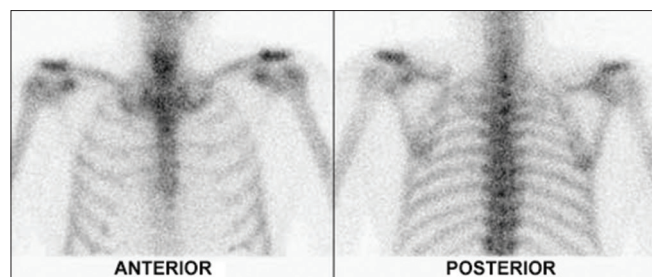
Bone scintigraphy showing focal increased uptake in both acromioclavicular joints
